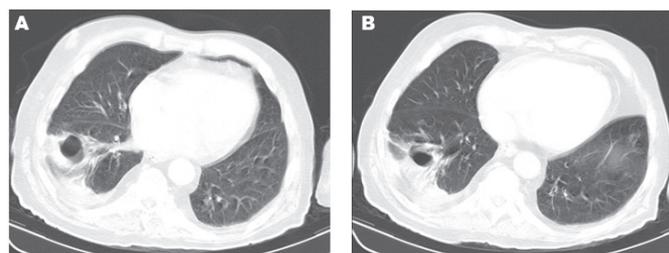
(A, B) Improvement on the chest computed tomography control.
